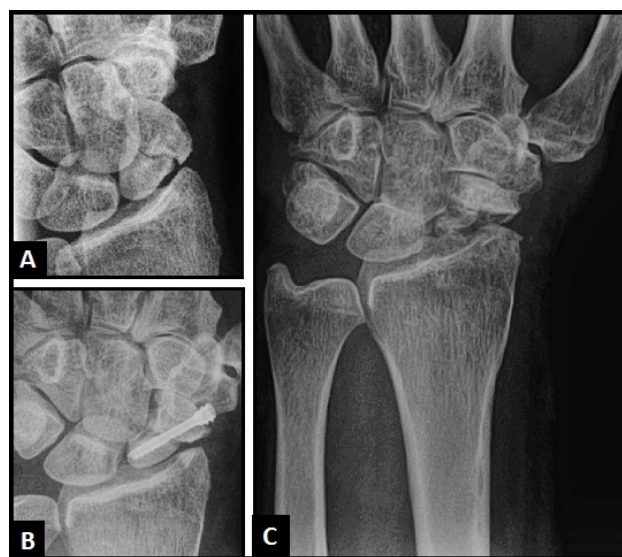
(A) PA radiograph showing scaphoid non-union; (B) PA radiograph showing migration of the headless compression screw at the distal pole of collapsing scaphoid bone; (C) PA radiograph showing posttraumatic pancarpal wrist joint OA due to advanced stage of SNAC wrist with complete avascular necrosis of the proximal pole of scaphoid bone.
